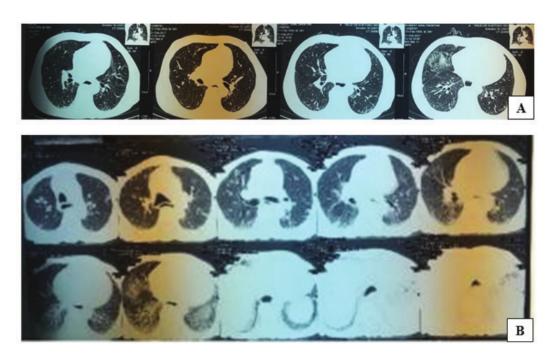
Chest HRCT in the first year (A) and in the second year (B)
